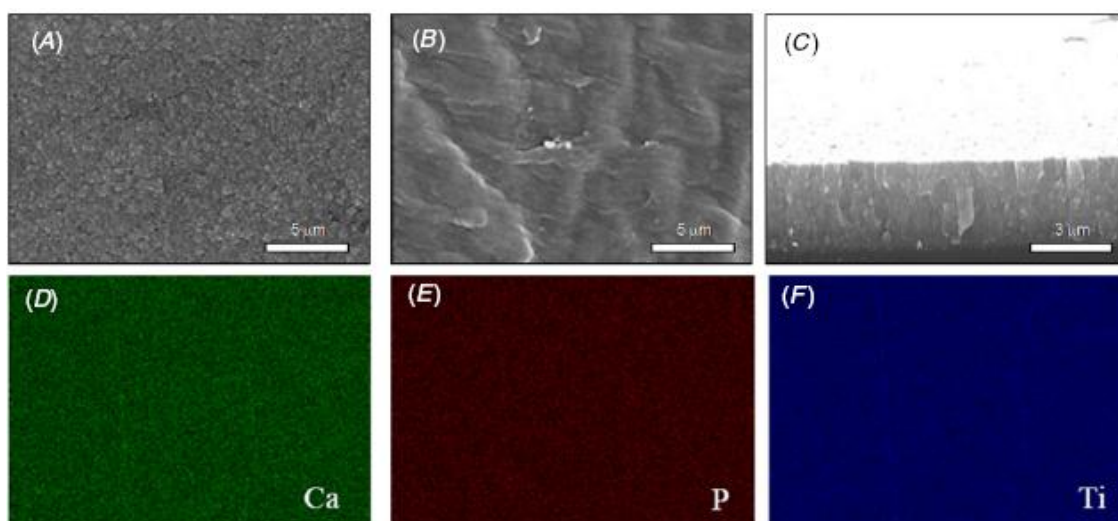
SEM morphology of the surface of cpTi-UHMWPE (A) and cpTi/HA-UHMWPE (B) samples. Cross section of a cpTi-UHMWPE sample (C). X-ray mapping of the surface of the cpTi/HA-UHMWPE samples for calcium (D), phosphorus (E) and titanium (F).
